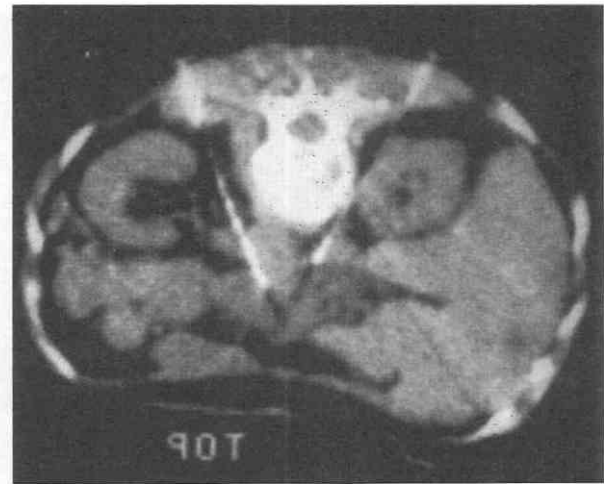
This CT procedure, which took place in 1976, shows the placement of two skinny needles for performance of a celiac nerve block (see text).
